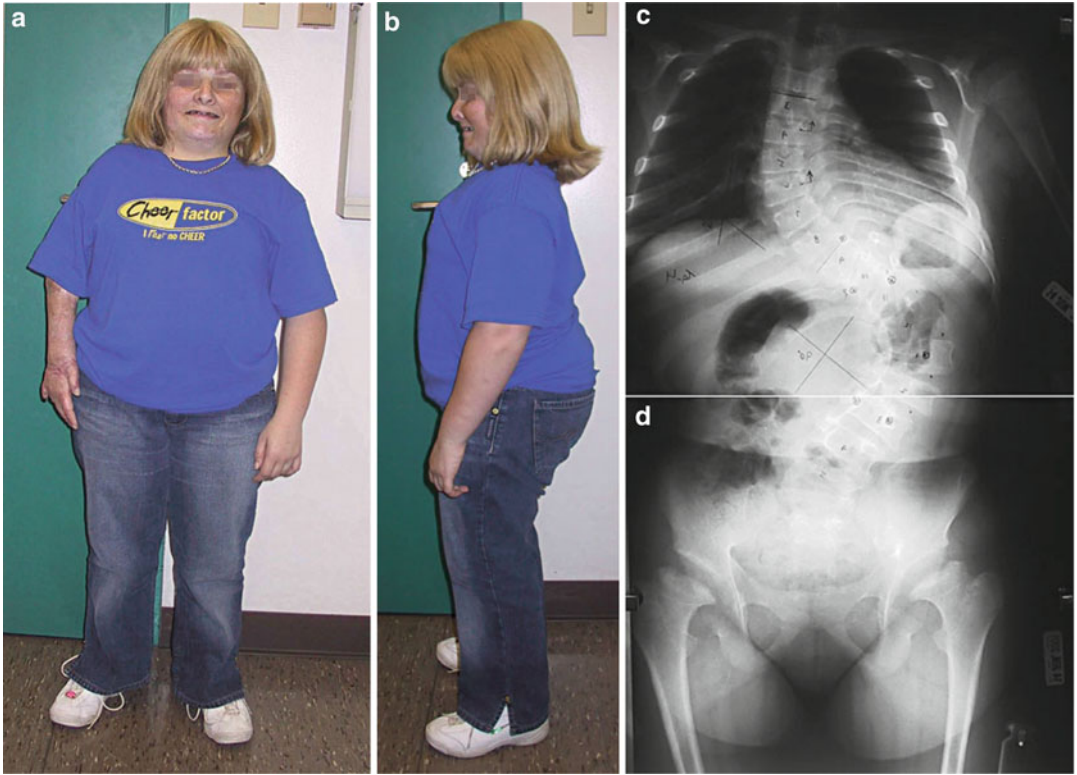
(a–d) An adult with SED showing short-trunk dwarfism. Radiographs showed flat vertebral bodies, severe scoliosis, and retarded ossification of femoral head and neck
